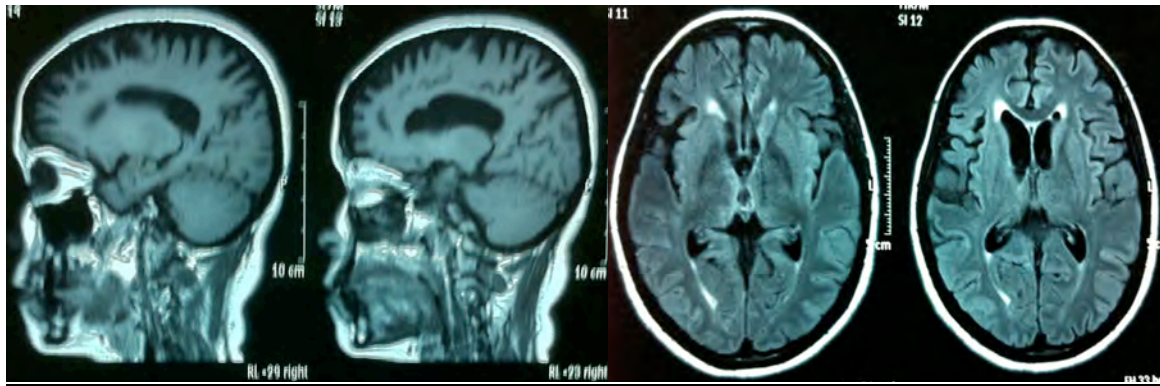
MRI Brain of T Images July 2011: reported as generalised atrophy
